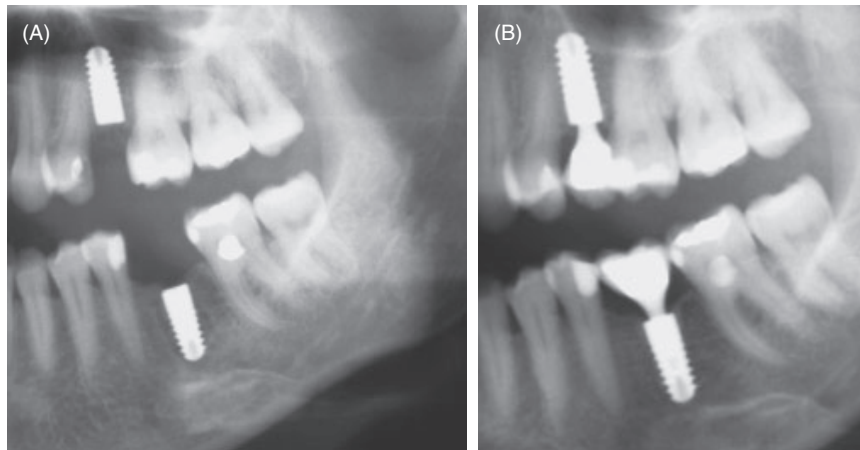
A, Radiographic evaluation after subcrestal placement of two implants in the maxilla and mandible (baseline). B, Radiographic evaluation after subcrestal placement of two implants (12 years follow-up) demonstrating crestal bone stability.
